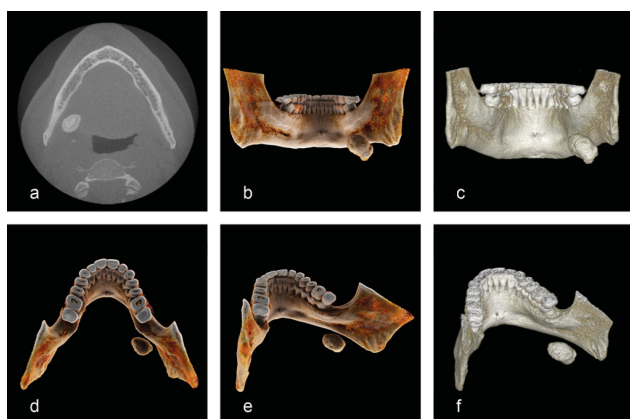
Paramedian (right) and ramus (left) fracture of the mandible: (a) frontal CT plane; (b) frontal CR view; (c) frontal conventional VRT view; (d) axial CT plane; (e) oblique CR view; (f) oblique conventional VRT view.
